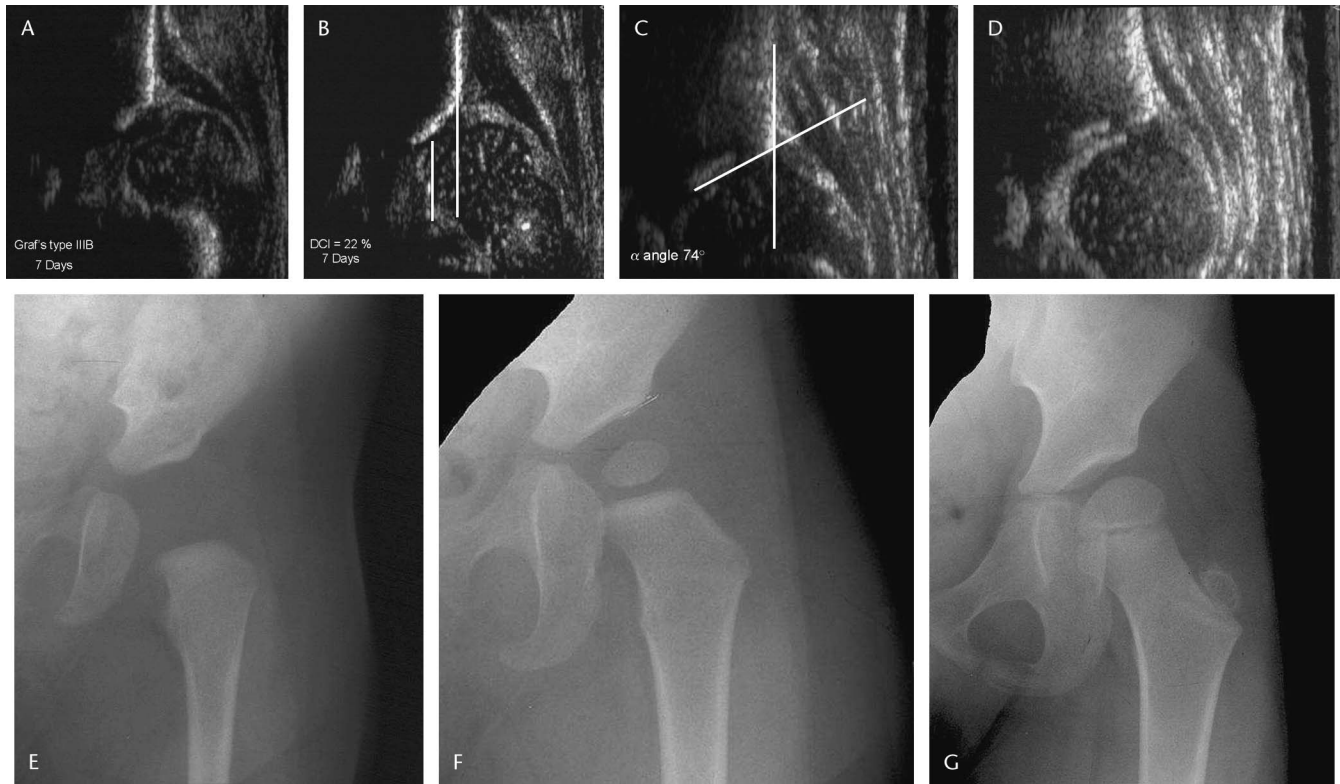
Serial sonograms and radiographs of a girl with left neonatal hip instability successfully reduced early in the Pavlik harness; at a follow-up of 5 years and 2 months the hip showed late acetabular dysplasia. A, Coronal neutral view sonogram at age 7 days shows severe dysplasia, Graf's type IIIB with an immeasurable alpha angle and echogenic, pathologically transformed cartilaginous roof. B, Coronal flexion view with adduction stress, showing the true severity of the hip instability, with DCI 22%. The femoral head is subluxated superiorly (cranial) and laterally from the acetabulum. C, Sonogram in coronal neutral view at age 14 weeks when harness wear was discontinued shows normal acetabular development: Graf's type IA with alpha angle 74 degrees and normal echogenicity of the cartilaginous roof. D, Coronal flexion view with adduction stress at age 14 weeks, showing stable hip with DCI 58%. E, Radiograph at age 1 year 3 months, acetabular index 29 degrees. Normal acetabular development. F, Radiograph at age 3 years 4 months, acetabular index 28 degrees. Mild acetabular dysplasia with rounding of the superior lateral bony margin. G, Radiograph at age 5 years 2 months, showing acetabular dysplasia as measured by Wiberg's center-edge angle of 12 degrees.
